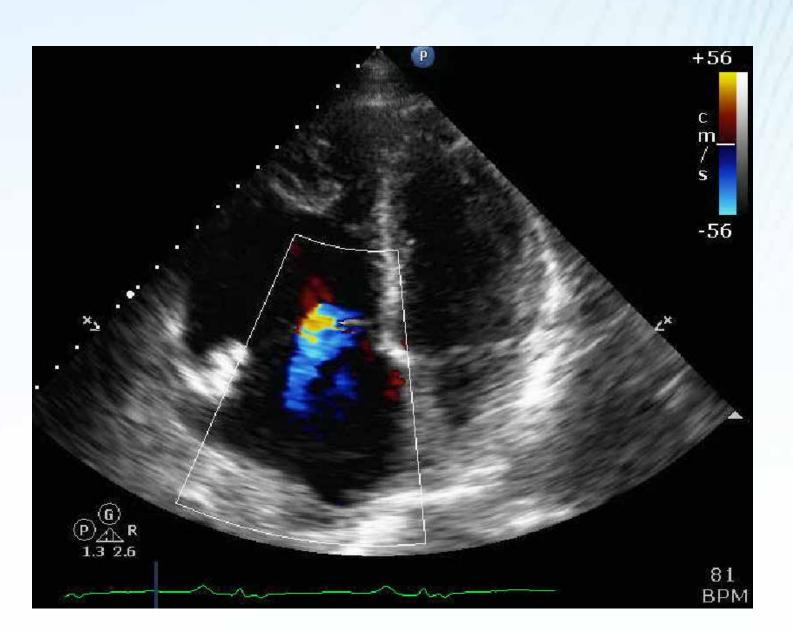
The four-chamber view with color Doppler image shows the marked dilatation of the right atrial and ventricular enlargement. We also noted tricuspid annular dilation with secondary, moderate tricuspid regurgitation.
